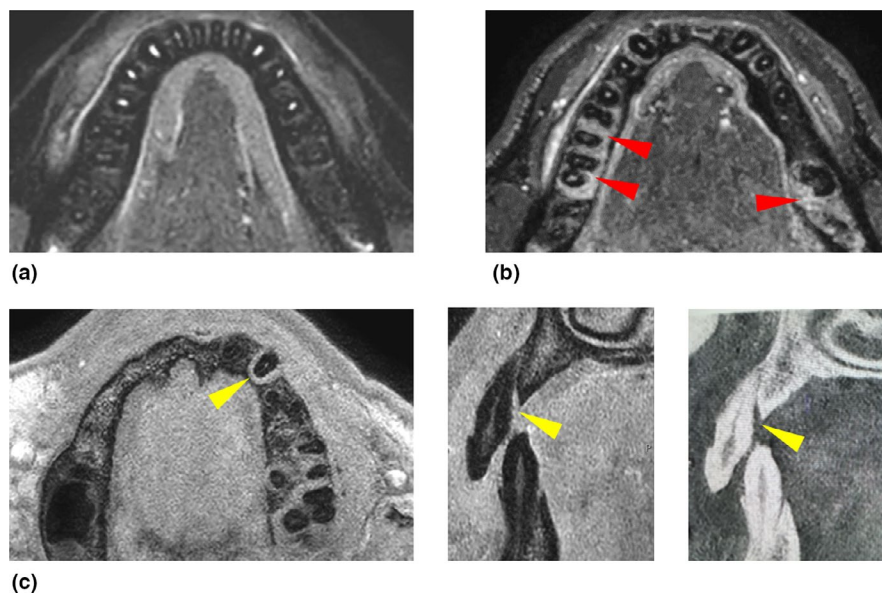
MRI sequences. (a) Axial plane of a 3D T2 STIR sequence in a healthy control subject showing dark signal values of healthy trabecular bone and high signal of healthy dental pulp. (b) Axial plane of a 3D T2 STIR sequences in a patient suffering from periodontitis with diffuse increase in T2 signal surrounding trabecular bone adjacent to molar teeth in both lower quadrants (red arrows). (c) Axial and sagittal reconstructions of a 3D T1 Black bone sequence showing the bone loss at teeth in the second quadrant (yellow arrows). Inversion of the signal (black into white) provides a CBCT or CT-like appearance resulting in a familiar image impression for the clinician
